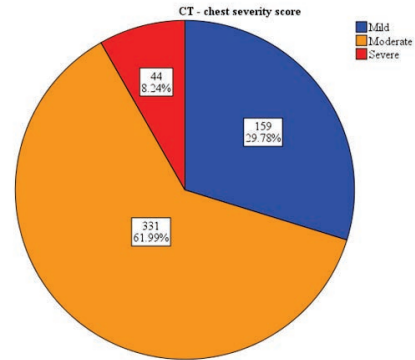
Distribution of individuals according to the CT-chest severity score category (n =534)
